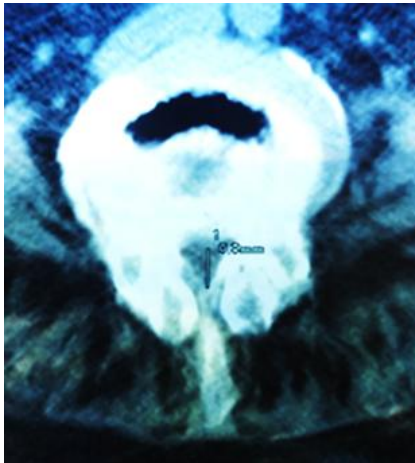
CT- narrowed neural foramen with pronounced hypertrophy of the apophyseal joints
